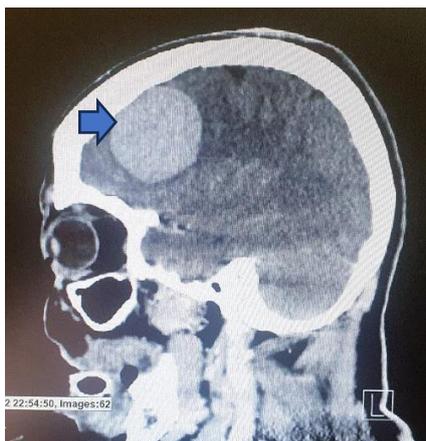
Computed tomography scan of sagittal view of the brain showing the meningioma.
